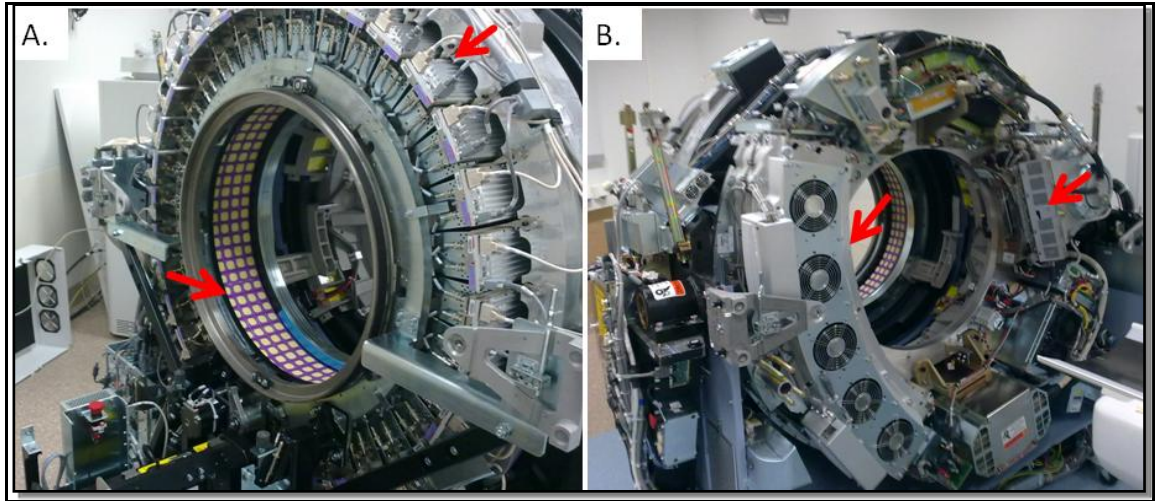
Photographs of the opened up gantry of PET-CT scanner (General Electric Discovery 690 PET-CT Scanner) A. PET assembly of the scanner; red arrows point to PET detectors (bottom left) and photo multiplier tubes (top right). B. CT assembly of the scanner; red arrows point to x-ray tube (right) and x-ray detectors (left). Image courtesy: Tony Shepherd, Turku PET Centre, Turku University Hospital (TYKS), Turku, Finland.
